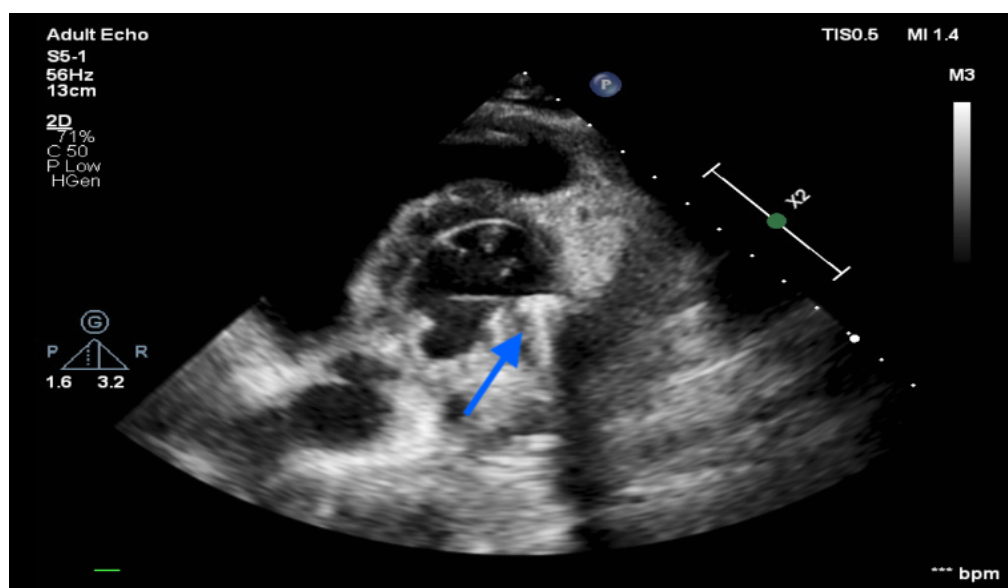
Preoperative echocardiogram image demonstrating prosthetic valve thrombosis (blue arrow).
